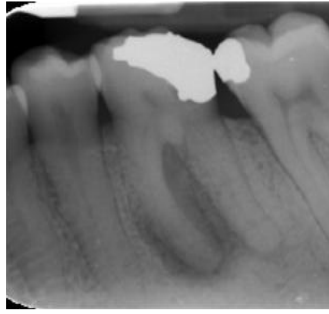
The presence of preoperative periapical radiolucency reduces the success rate of endodontic treatment from 96% (where no pre operative periapical radiolucency is present) to 86%.²
